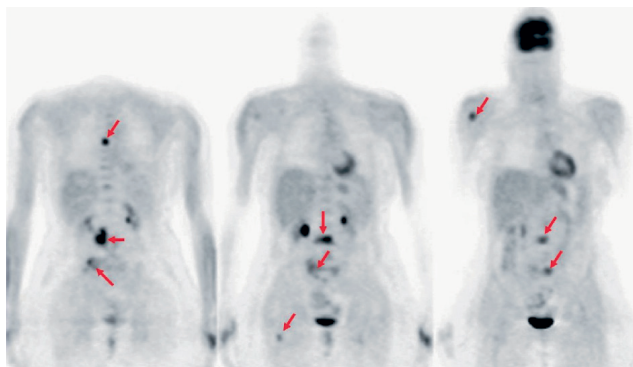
FDG PET scan of a patient with metastatic high grade chondrosarcoma in coronar slices. Multiple bones metastases with intense tracer uptake (arrows). Physiologic tracer uptake can be seen in brain, heart muscle, kidneys and urine bladder.
